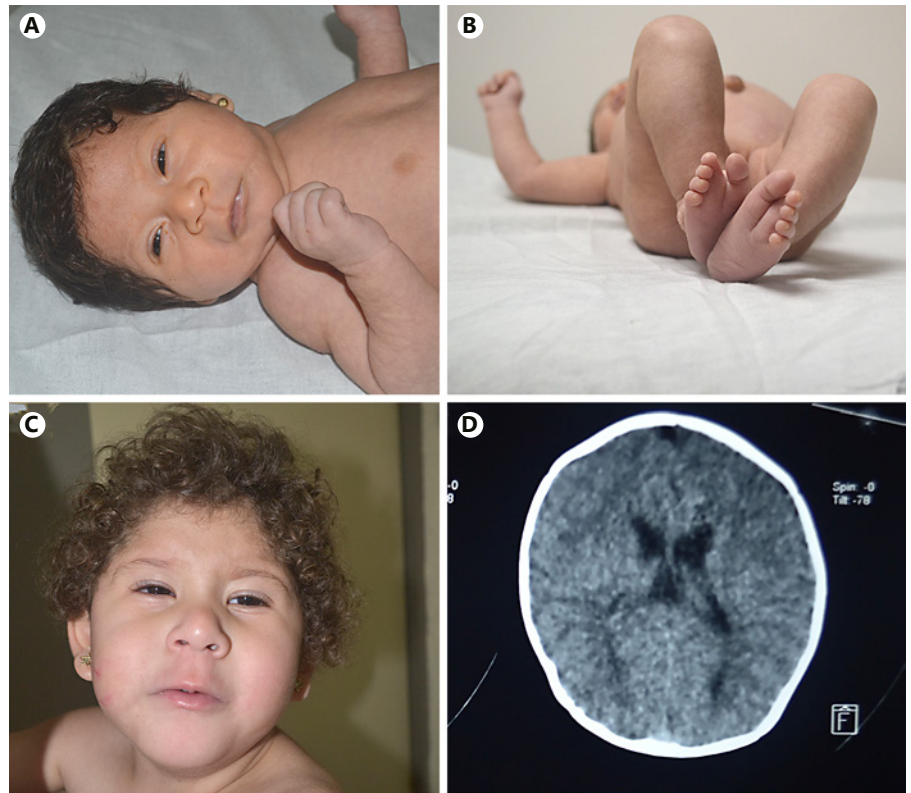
Photographs of the patient at the age of 1 month (A) and 3.2 years (B). A Appraisable facial features include round face with prominent cheeks, wide forehead, narrow palpebral fissures, short nose with anteverted nostrils, long philtrum, and prominent columella. B Note the bilateral deep plantar crease. C The patient also presents curly, brown hair. D Cranial axial CT image (at the age of 7 months), suggesting a typical sign (“racing car sign”) for agenesis/hypoplasia of the corpus callosum.
